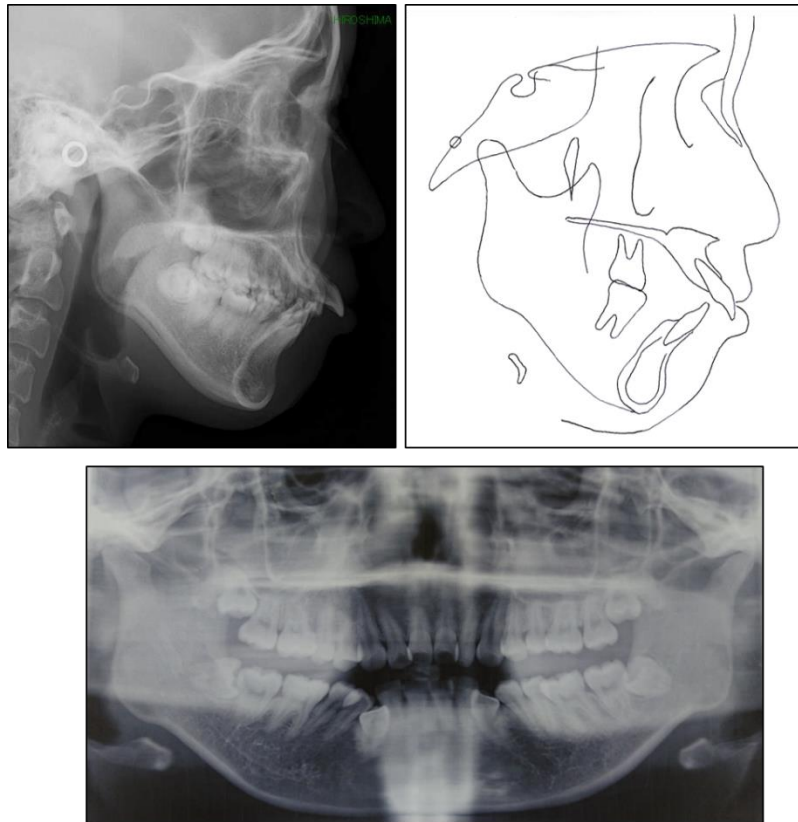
Pretreatment panoramic, lateral cephalometric radiograph and cephalometric tracing.
